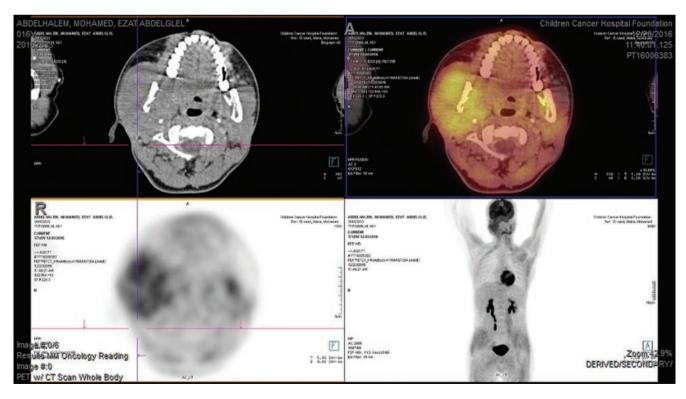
Axial and MIP images of PET/CT and fused18F-FDG-PET/CT images of patient number 2 at initial staging showing: right mandibular mass lesion with SUVmax 4 associated with enlarged right cervical LNs with low grade FDG uptake
